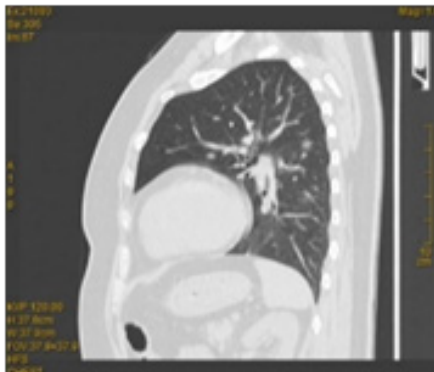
A chest CT of patient named ZAW who was tested positive for new coronavirus nucleic acid.
